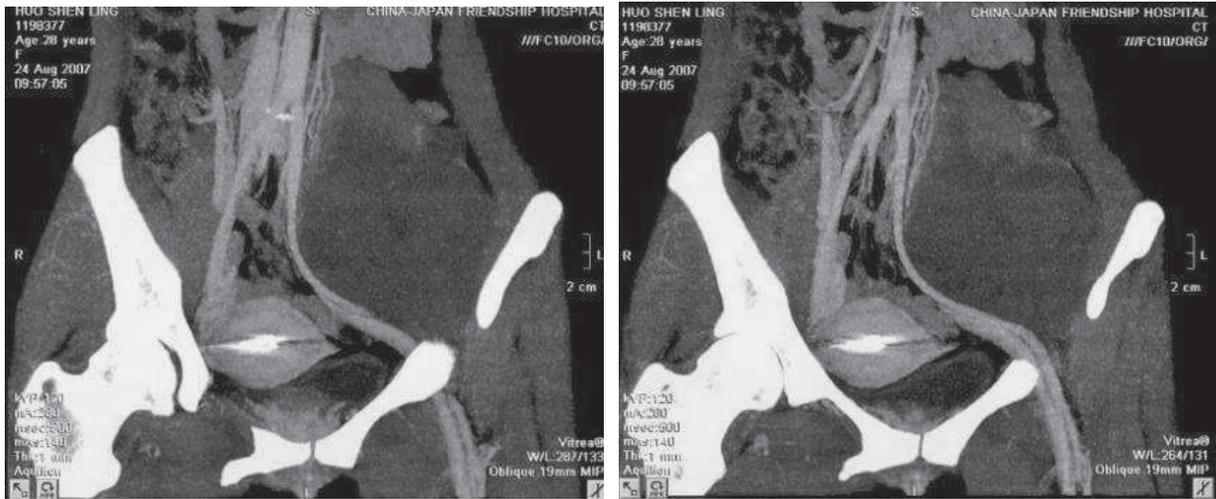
CT scan imaging
